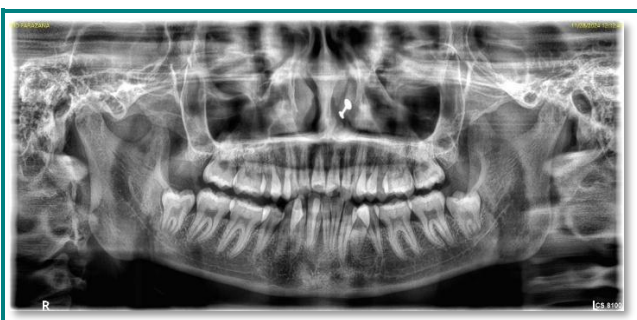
Orthopantomogram showing generalized bone loss.
